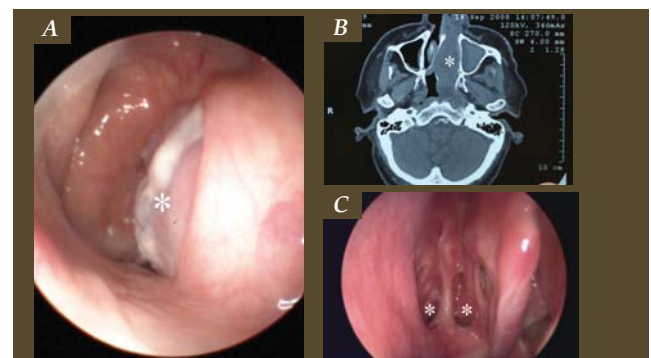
Haemangiopericytoma\* arising from the nasal septum, viewed from the right side of the nasopharynx (A); Axial CT showing the tumour\* (B); Operative site with nasal septum resected, viewed from the right nasal cavity 4 months after surgery (C) (\* normal right and left sphenoid sinus ostium)
